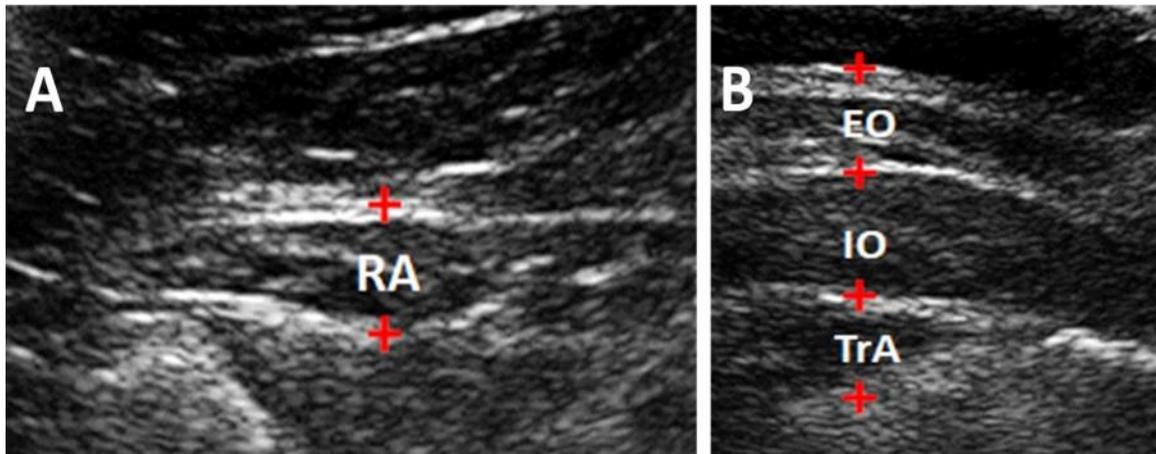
Ultrasound images of the abdominal muscles of Participant 1—affected side
